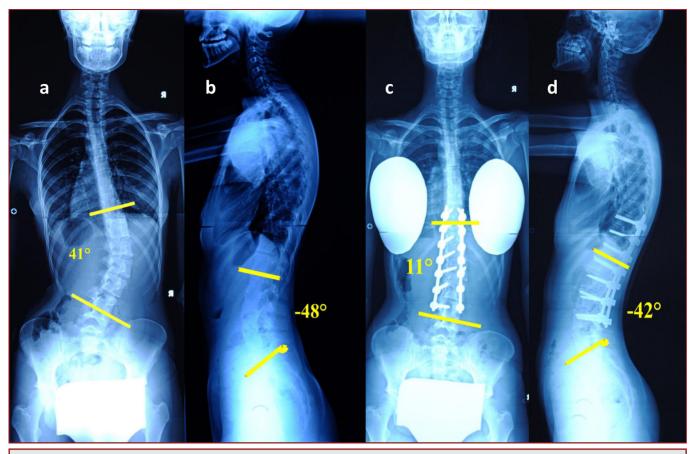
16-year-old girl with Lenke Type-5 AIS. a-b) Preoperative and c-d) last follow-up Xrays after selective posterior fusion
